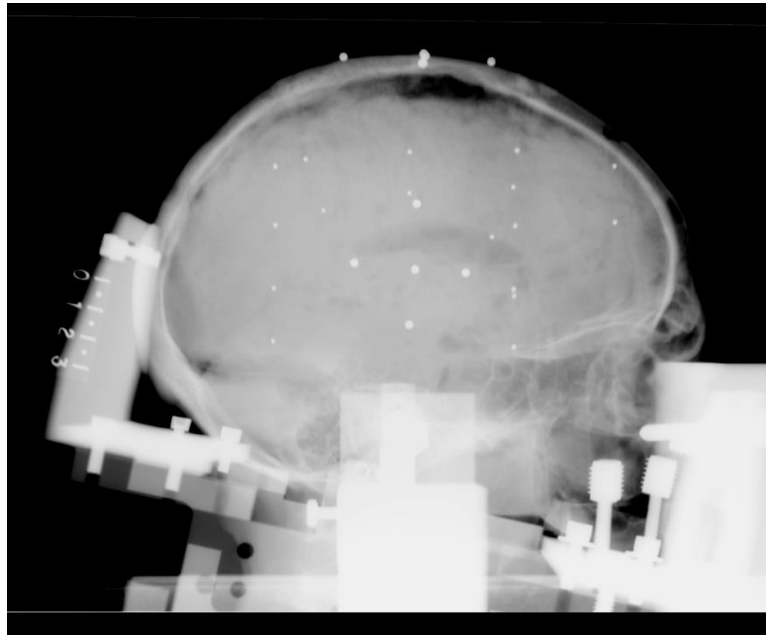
Plain x-rays of final brain target deployment and skull target fixation in Series A.
